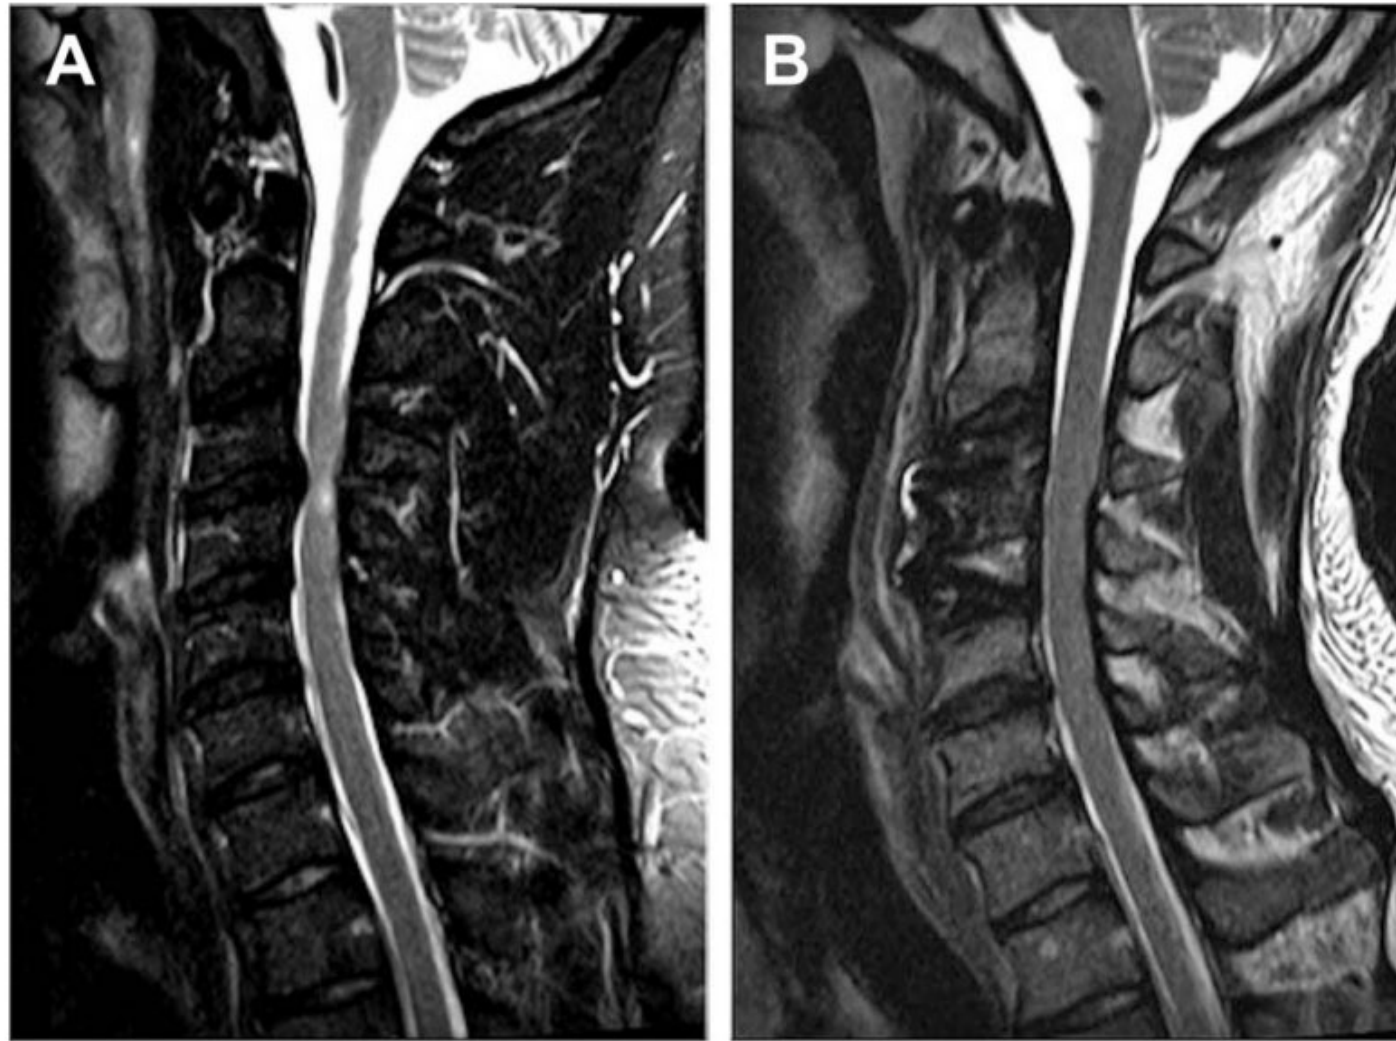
T2-weighted sagittal MRI (A) demonstrating preoperative hyperintensity at C3/C4 and (B) resolution of hyperintensity 6 months after surgery.
